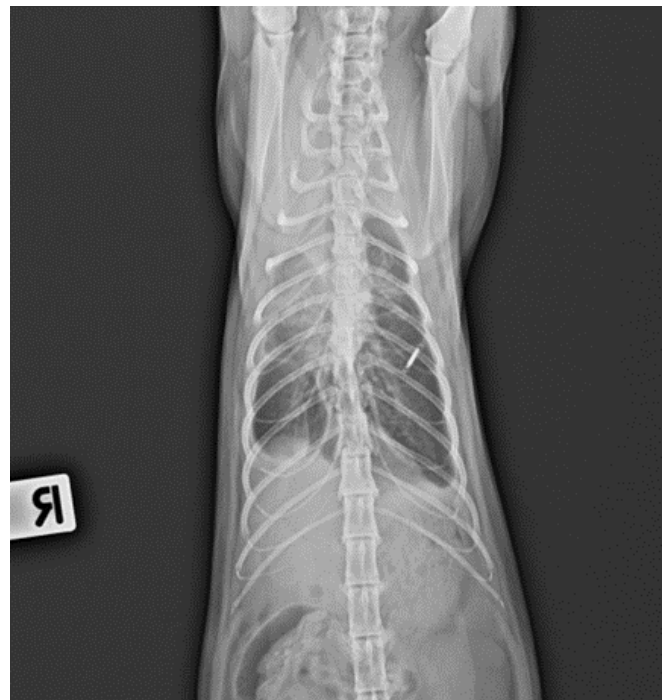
Thorax VD radiography – after two weeks of rutin (plant-based bioflavonoid) treatment.
